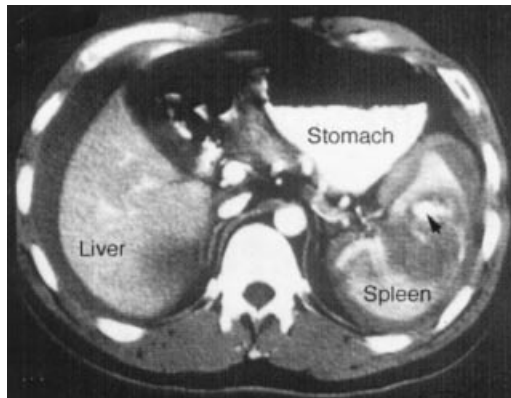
CT scan through the upper abdomen. The arrow points to a hematoma (a pool of blood) in the spleen. The density difference between the blood and surrounding tissues is about 5%. Courtesy of Dr. Richard Wechsler, Thomas Jefferson University.
